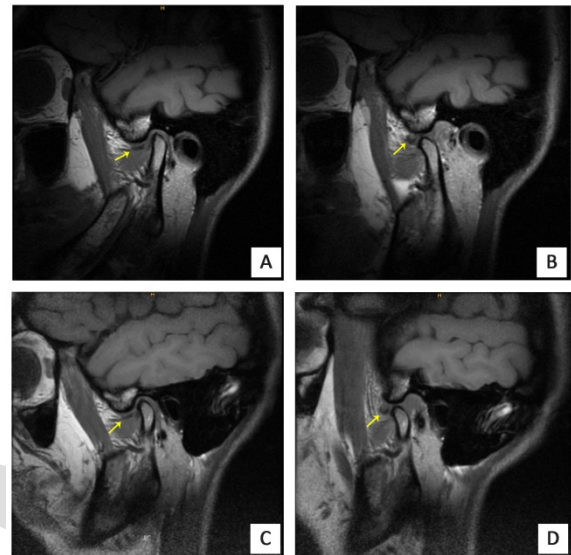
A-B preoperative MRI, sagittal view, T1 sequence, the arrow refers to the anteriorly displaced disc in both closed and open mouth positions respectively, C-D 6M PO MRI, sagittal view, T1 sequence, the arrow refers to the persistently displaced disc in both closed and open-mouth positions.
